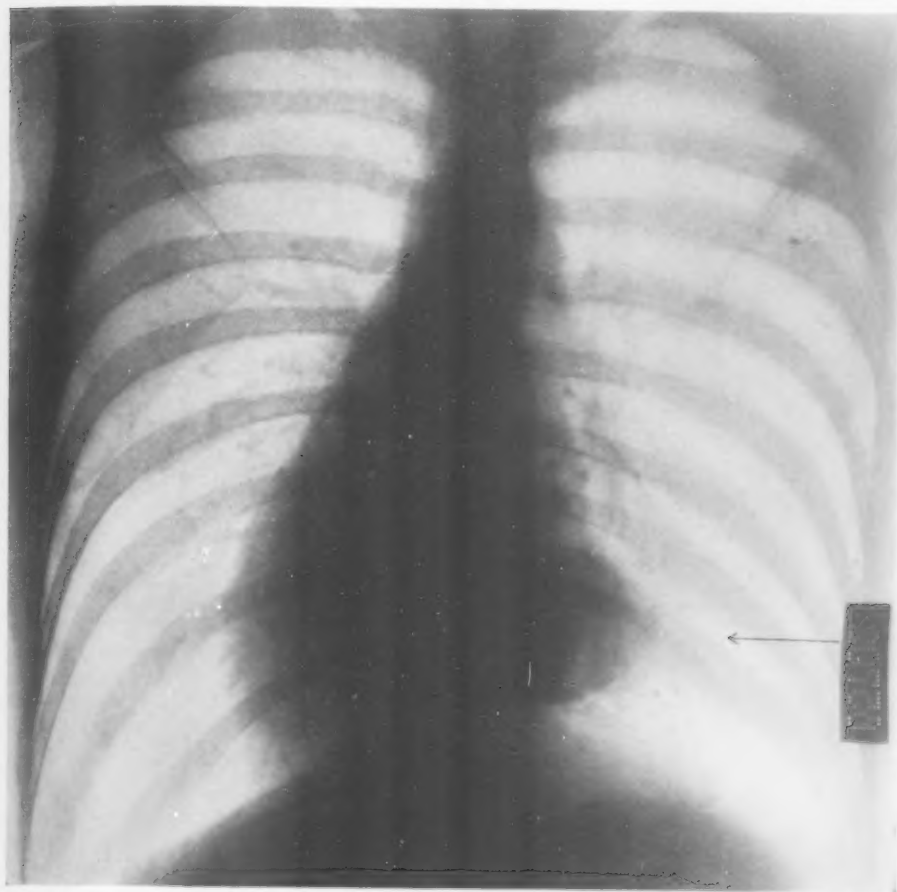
X-ray of Case III. Antero-posterior view showing the shadow of a tumor to the right of the cardiac shadow.
